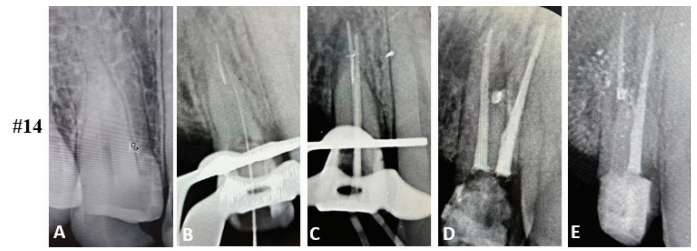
Endodontic Treatment of #14 (A): A Preoperative X-ray (B): Broken file in the Buccal Canal (C): Master cone (D): Obturation (E): Post preparation
